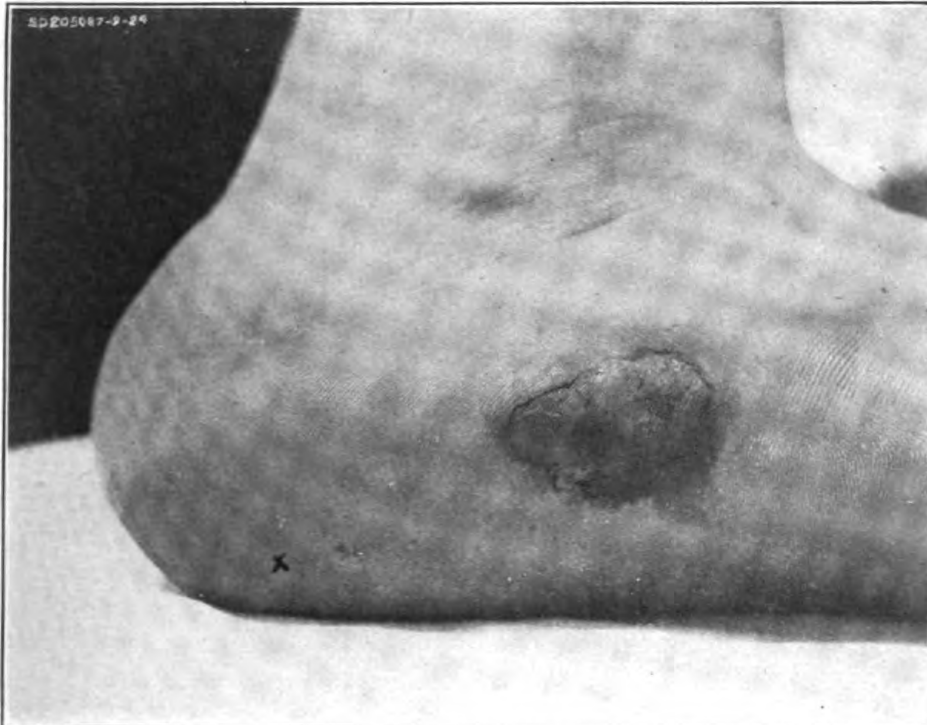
DEEP ULCER ON MESIAL ASPECT OF SOLE, SHOWING MARGI-NATE CHARACTER
